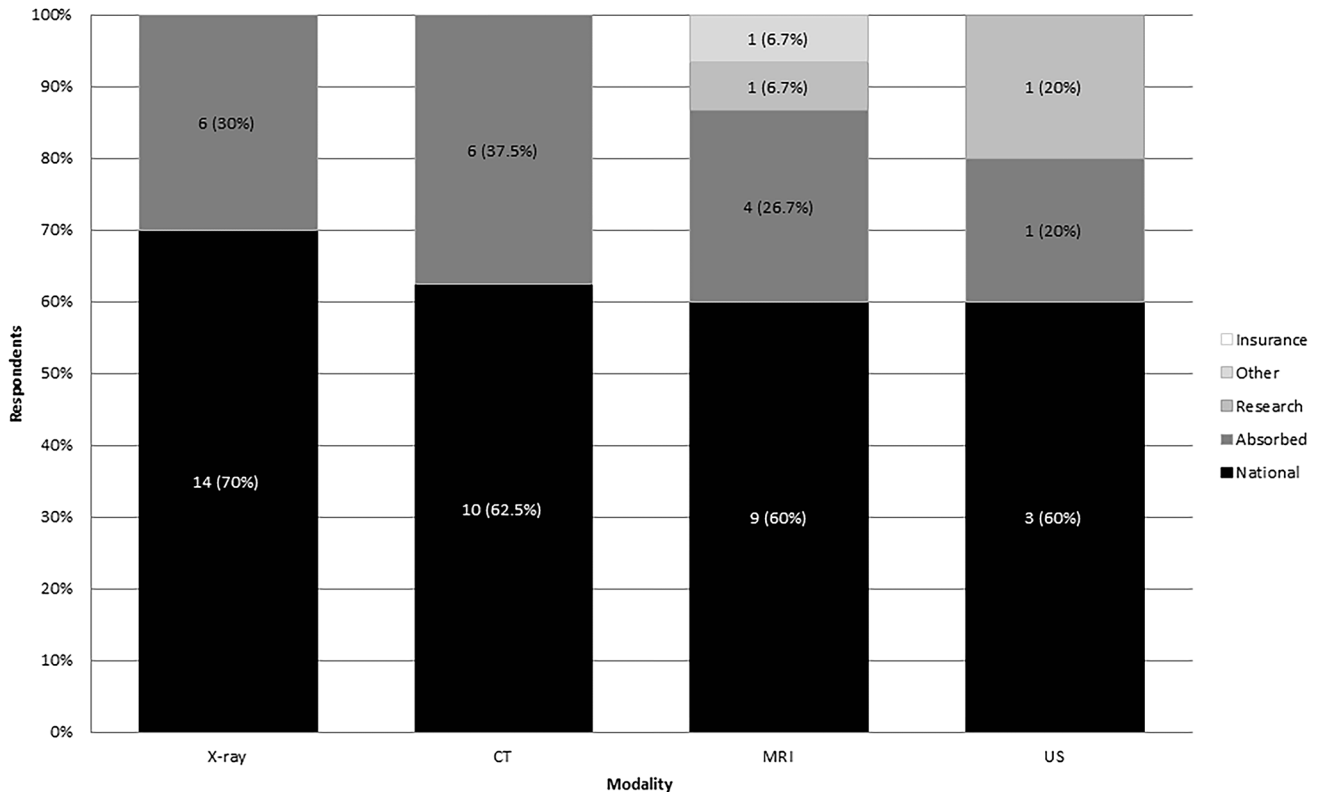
Current reimbursement streams for medical (i.e. non-forensic) postmortem imaging (PMI) by modality. Other=cost paid by referring hospital. Total responses: X-ray 20; computed tomography (CT) 16, magnetic resonance imaging (MRI) 15 and ultrasound (US) 5
